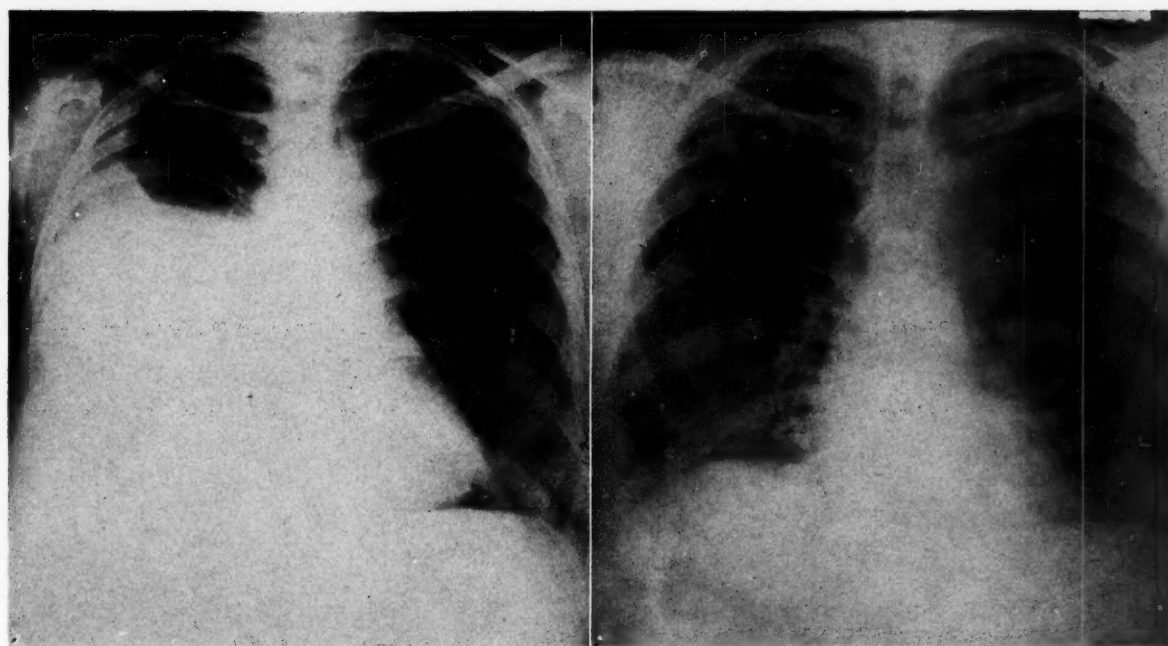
X-rays of the chest of Case I. A, before the first thoracentesis; B, fifteen weeks postoperatively.
